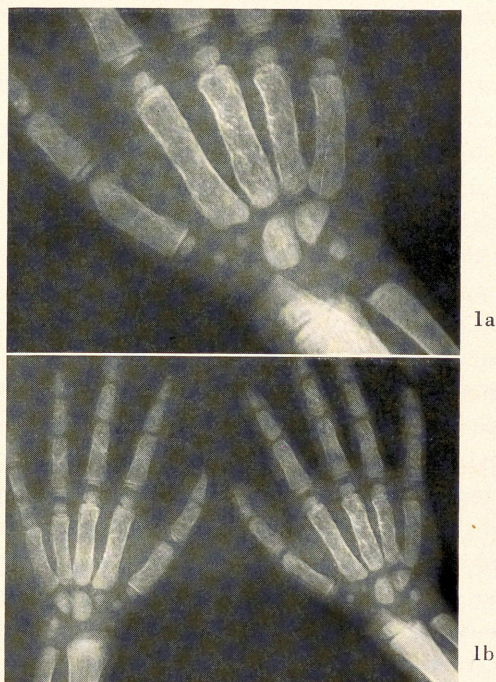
X-ray of the hands showing bone changes from a case of Hb. E-thalassaemia disease.
